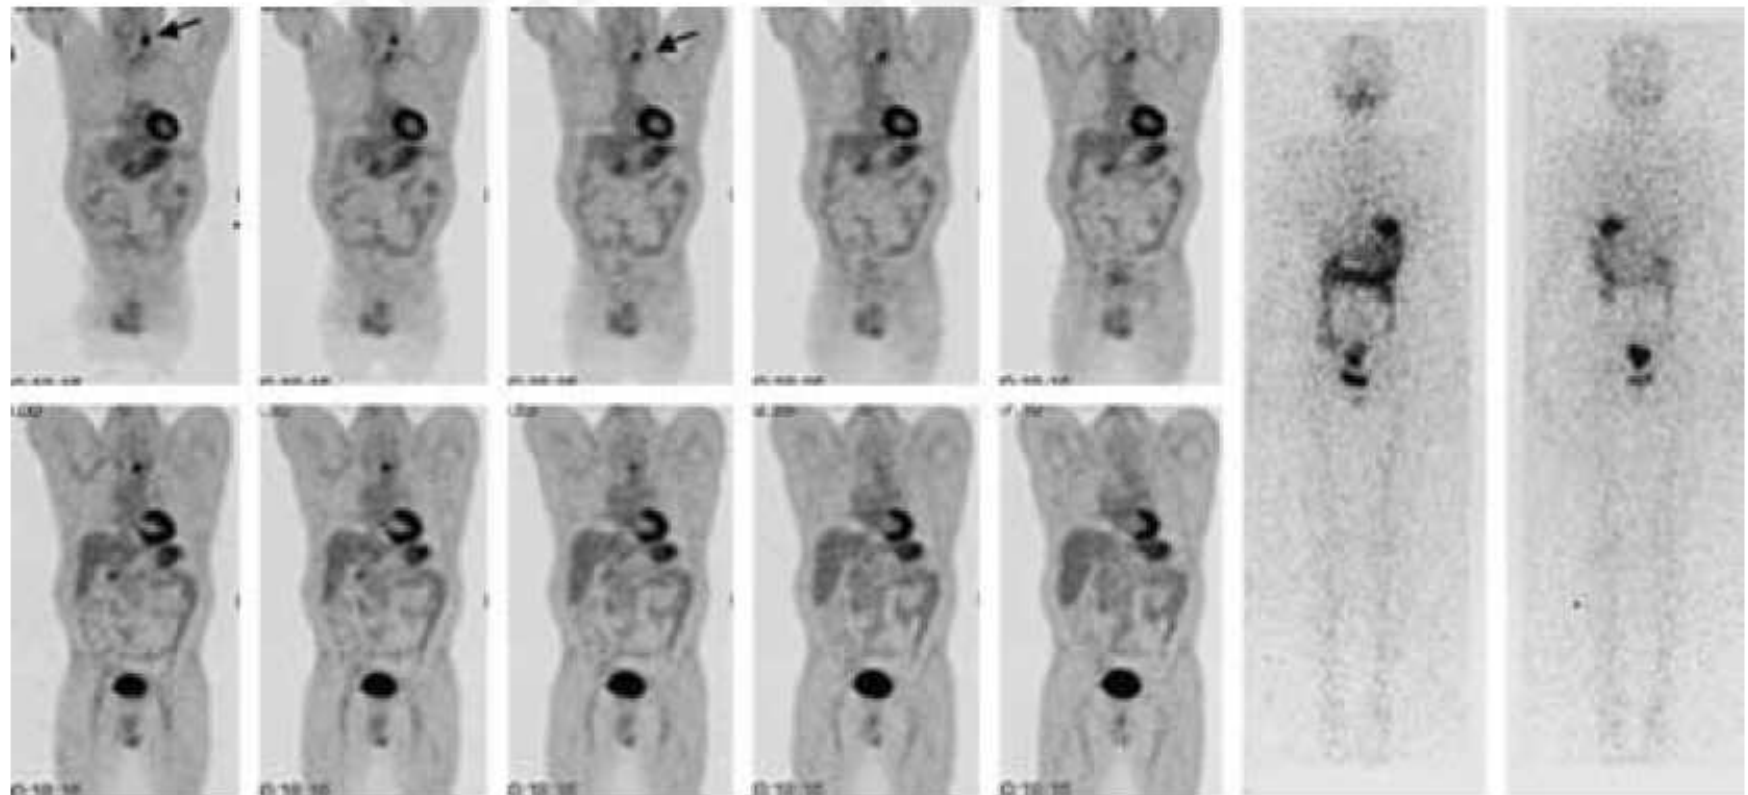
A 62-year-old male patient with positive FDG-PET/CT and negative post-therapy ^{131}I whole-body scan. Human thyroglobulin level at short-term follow-up was sensibly higher (200 ng/mL) than before therapy (100 ng/mL).
